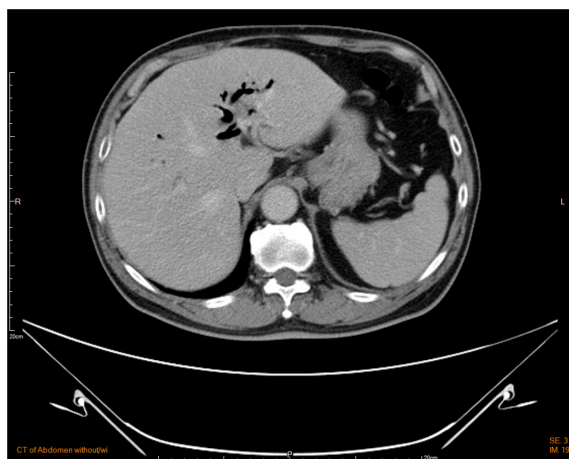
Computed tomography scan of the abdomen demonstrated gas retention in the intrahepatic ducts, suggesting pneumobilia.
